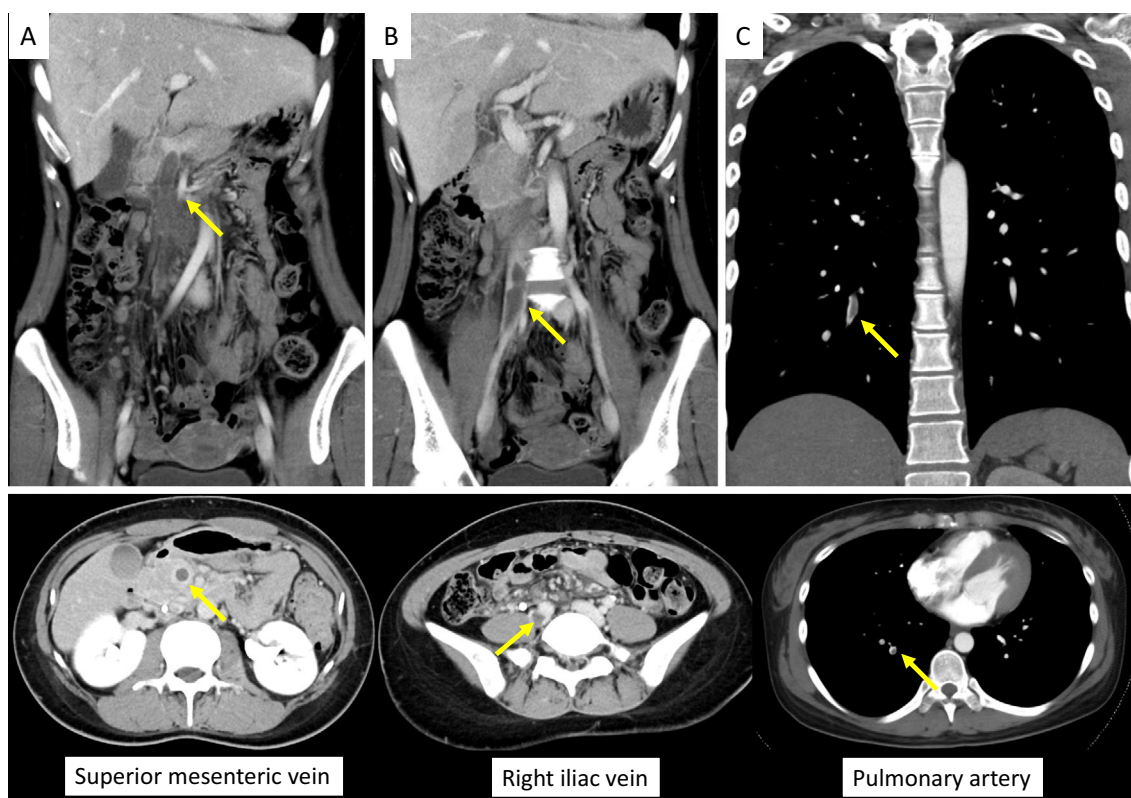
Contrast-enhanced computed tomography images. Coronal (top) and axial (bottom) images of the chest and abdomen at admission. Yellow arrows indicate thrombi in the (A) superior mesenteric vein, (B) right iliac vein, and (C) peripheral branch of the right inferior pulmonary artery. (A) and (B) show increased fat concentration in the intestinal membrane without bowel wall thickening or intestinal pneumatosis. CECT: contrast-enhanced computed tomography
